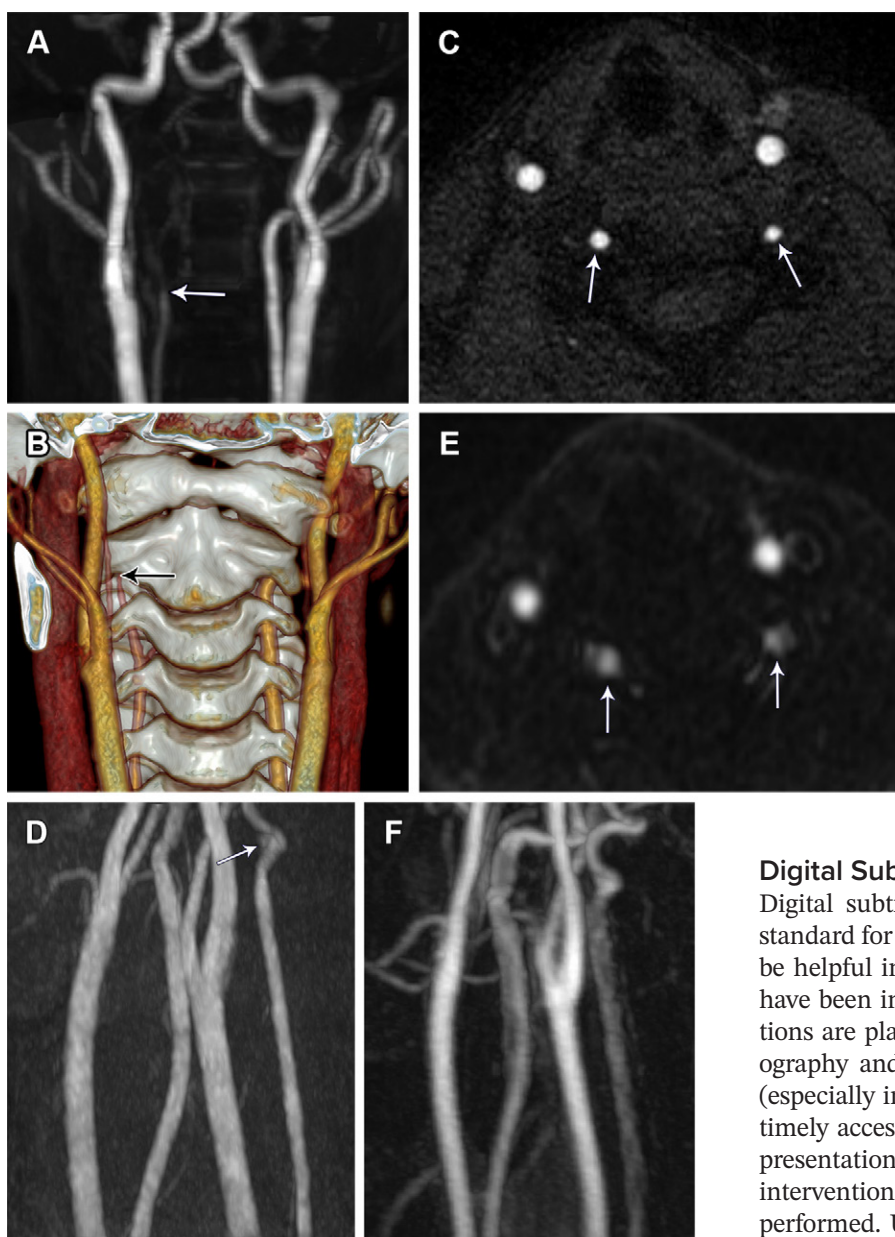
VAD in two children. The advantages and disadvantages of TOF MR angiography and contrast-enhanced imaging (CT angiography in case 1 [A, B]; contrast-enhanced MR angiography in case 2 [C–F]) in the assessment of VAD are highlighted. (A, B) Comparison of a coronal 2D TOF MIP MR angiogram (A), showing occlusion of the right vertebral artery (arrow in A), with an anterior volume-rendered CT angiogram (B) in a 10-year-old girl with headache, nausea, neck pain, and right arm weakness (case 1) shows that the nonenhanced TOF MR angiogram (A) inaccurately characterized the level of occlusion, which was more distal at the C2 vertebral body level (arrow in B), due to slow flow proximal to the obstruction. (C–F) In a 12-year-old girl who presented with headache, visual disturbance, and tongue and mouth numbness (case 2), axial 3D TOF MR angiography was superior to contrast-enhanced MR angiogram. The nonenhanced axial (C) and sagittal oblique MIP (D) 3D TOF MR angiographic images of the vertebral arteries (arrows in C) had higher spatial resolution and better depicted a left vertebral artery pseudoaneurysm (arrow in D), compared with the contrast-enhanced axial (E) and sagittal oblique MIP (F) MR angiographic images. The pseudoaneurysm is obscured by the periarterial venous plexus on the MIP MR angiographic image (F). 3D TOF MR angiography and contrast-enhanced CT or MR angiography may be complementary studies.
